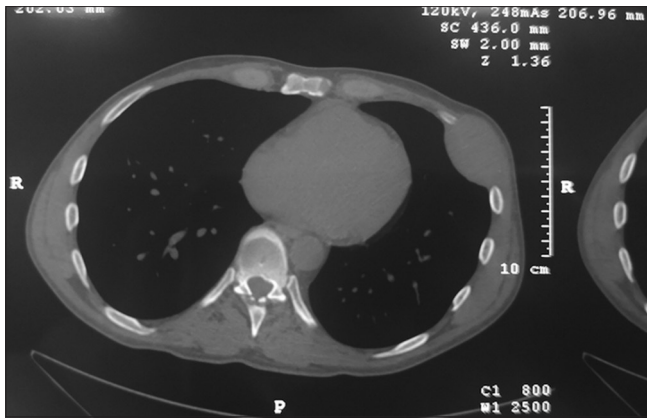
Computed tomography scan of the chest showing a mass on the left chest wall with osteolytic lesions
